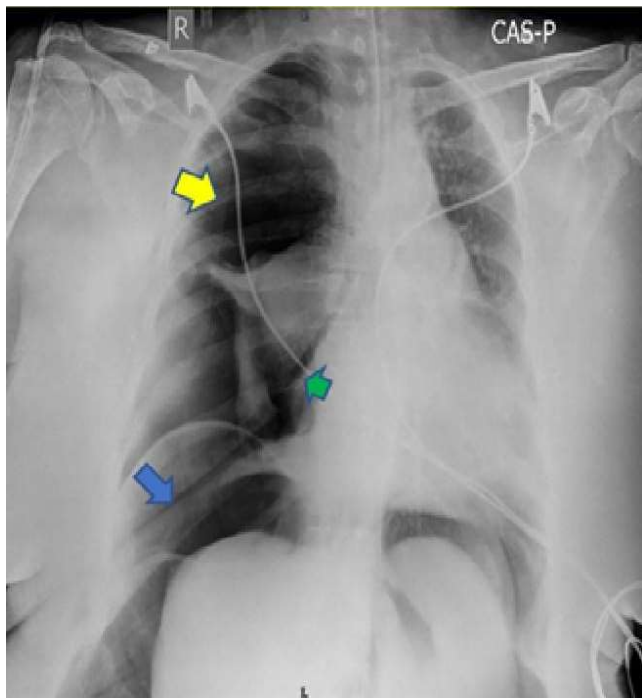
Chest X-ray showing Pneumothorax (yellow arrow), Pneumomediastinum (green arrow), and Pneumoperitoneum (blue arrow)
